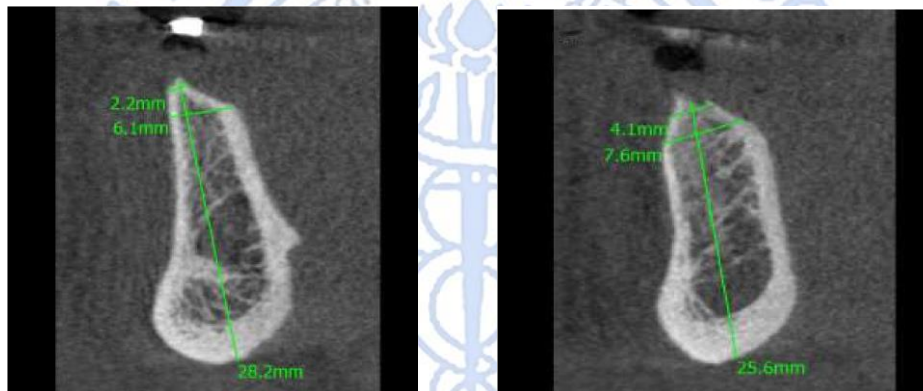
CBCT analysis of the implant sites
